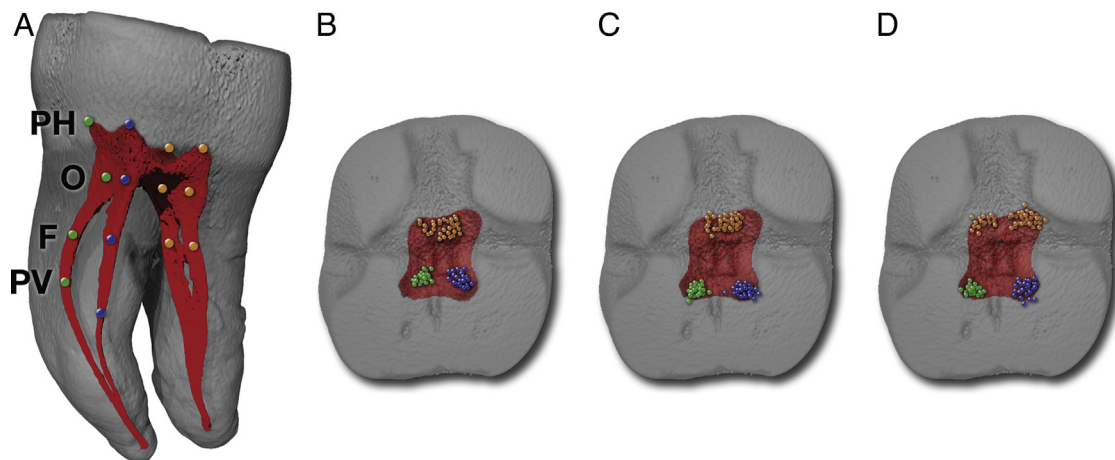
(A) Three-dimensional volumetric representation of μ CT data showing selected landmarks: pulp horns (PH), center of canal orifices at the pulp chamber floor (O), center of canal at the furcation level (F), and center of primary curvature in the maximum view (PV). Projection of individual landmarks onto a semitransparent occlusal surface template of an ideal mandibular molar: (B) canal orifices, (C) canal position at the furcation level, and (D) pulp horns. Green dots represent MB landmarks, blue dots ML landmarks, and orange dots the DB and DL landmarks.
